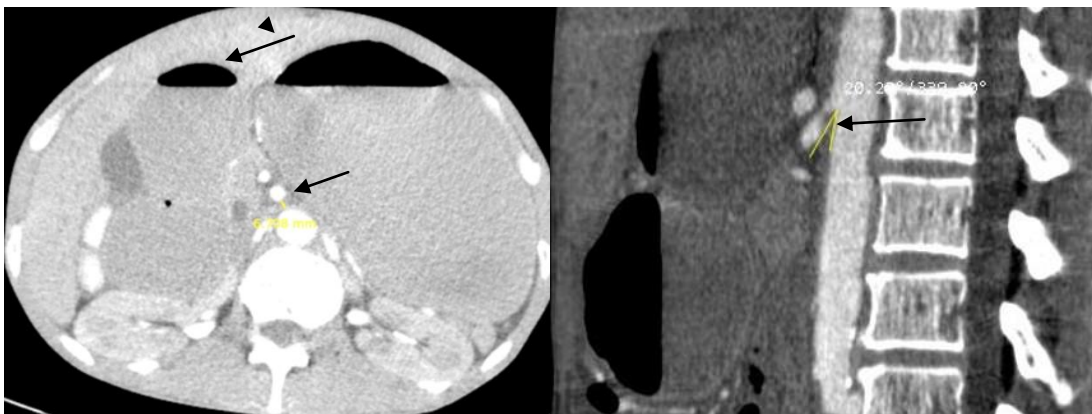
(A,B).CT criteria suggestive of SMAS. Selected contrast enhanced mid abdominal axial (A) and mid sagittal (B) images demonstrating reduced AMD (small vertical line in region of interest in image A), dilated proximal second part of duodenum (arrow in image A), and reduced AMA (arrow in image B).
